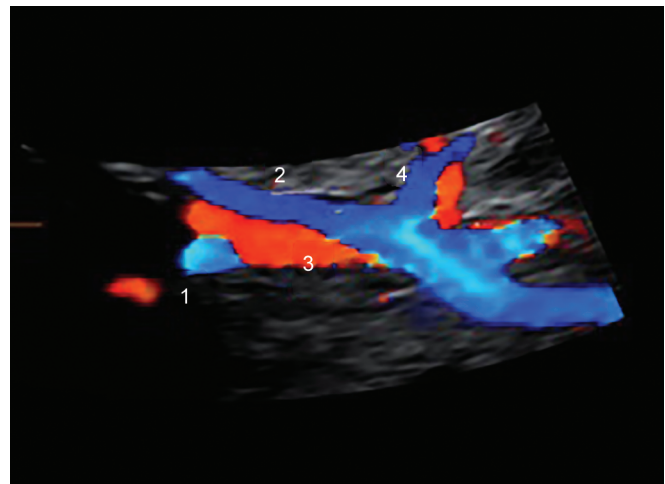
3D-rendering plus Color Doppler demonstrate the right IVC (1), the left IVC (2), crossing the aorta (3) after receiving the left renal vein (4)
